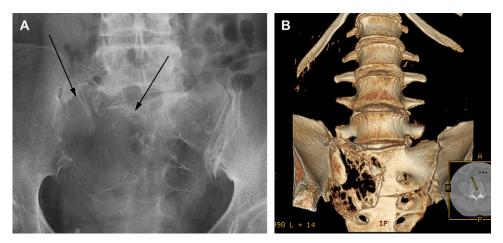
(A) Plain radiograph and (B) three-dimensional CT reconstruction of a large sacral GCT. Arrows indicate location of tumor on radiograph. (Courtesy of J. Chi, MD, MPH, Baltimore, MD.)
